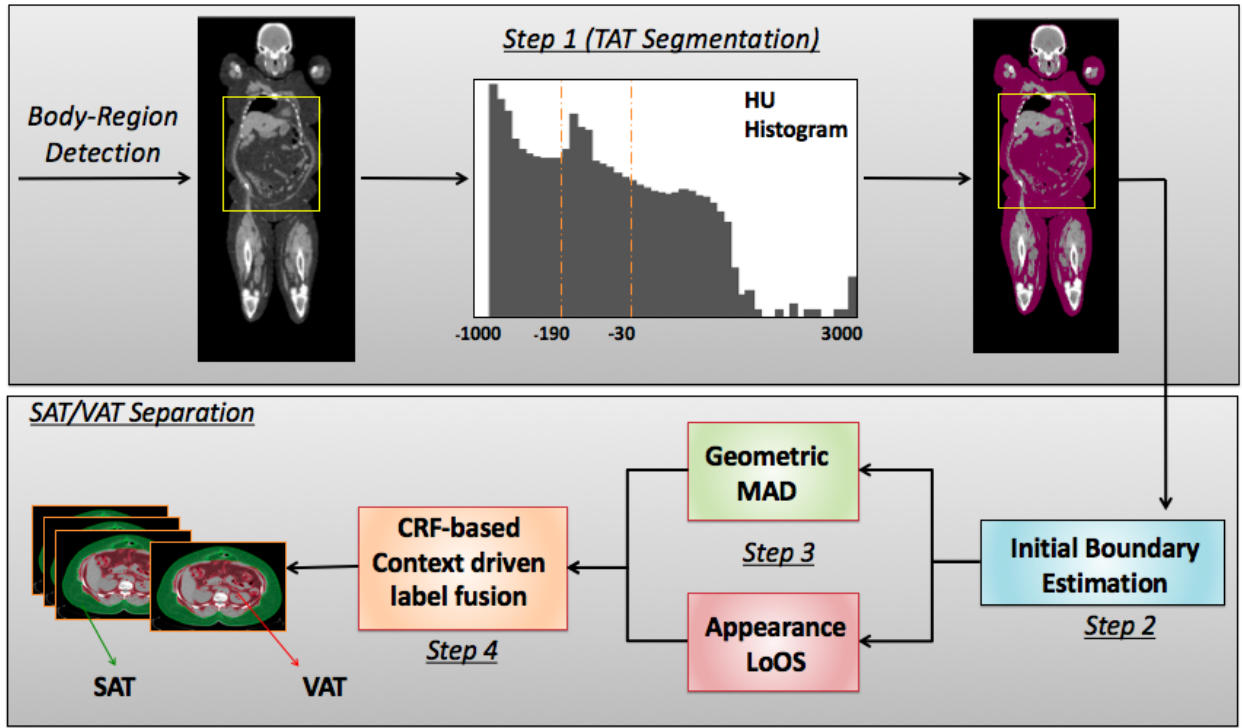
An overview of the proposed SAT-VAT separation method. Once the abdominal region is detected, Total Adipose Tissue (TAT) is segmented using the CT intensity interval known for fat tissue. Initial Subcutaneous-Visceral adipose tissue boundary is estimated by evaluating multiple hypothesis points. Geometric Median Absolute Deviation (MAD) and appearance based Local Outlier Scores (LoOS) are then combined within the 3D Conditional Random Field (CRF) based label fusion.
